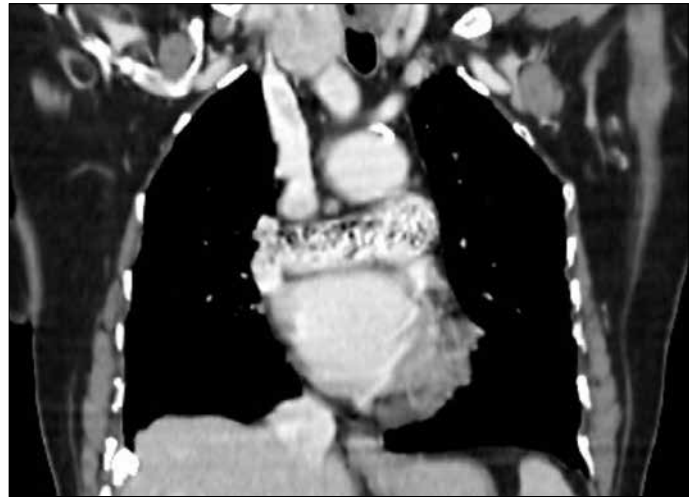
Coronal thoracic CT cross section
